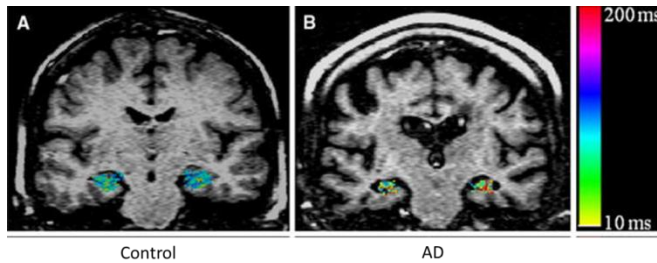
T1 ρ - weighted MRI maps in human subjects with Alzheimer's Disease.
